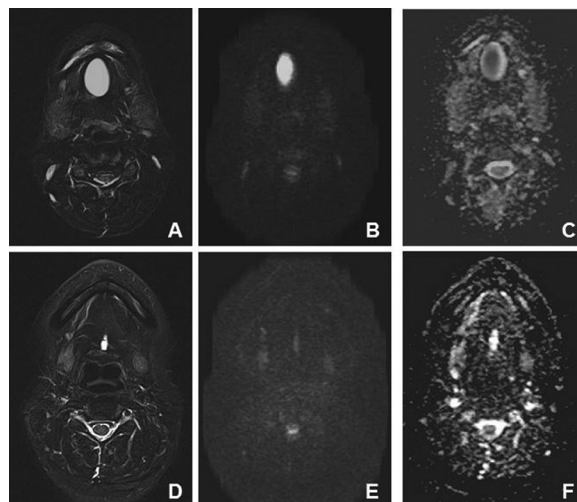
The MRI findings of an epidermoid cyst (A, B, C) and a thyroglossal duct cyst (D, E, F) as examples of cystic masses or lesions that may have cyst-like components other than ranulas on STIR (A, D), DWI (B, E), and the ADC map (C, F). The epidermoid cyst had an oval outline, unlike ranulas (A, B). The ADC map of the epidermoid cyst (C) showed a value of $1.39 \times 10^{-3} \text{ mm}^2/\text{s}$, lower than that of ranulas. The ADC values of these cysts were significantly lower than those for ranulas. Thyroglossal duct cysts were located in the midline of the oral floor, and they did not continue to the sublingual glands (D, E). The ADC map of the thyroglossal duct cyst (F), had an ADC value of $2.48 \times 10^{-3} \text{ mm}^2/\text{s}$, relatively similar to ranulas. The ADC values of thyroglossal duct cysts were not significantly different from ranulas. *ADC*, apparent diffusion coefficient; *DWI*, diffusion-weighted imaging; *MRI*, magnetic resonance imaging; *STIR*, short-T1 inversion recovery.
